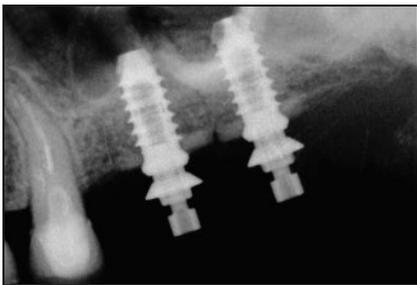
Case 2: Postoperative periapical radiographs following implant placement.
